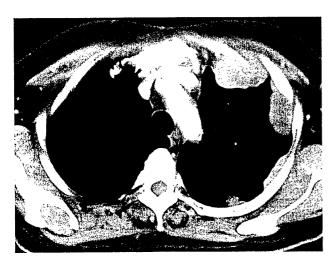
Chest computed tomography scan shows multiple pleural nodules in the left thorax in patient 5. This patient also had an ipsilateral axillary lymph node metastasis.
